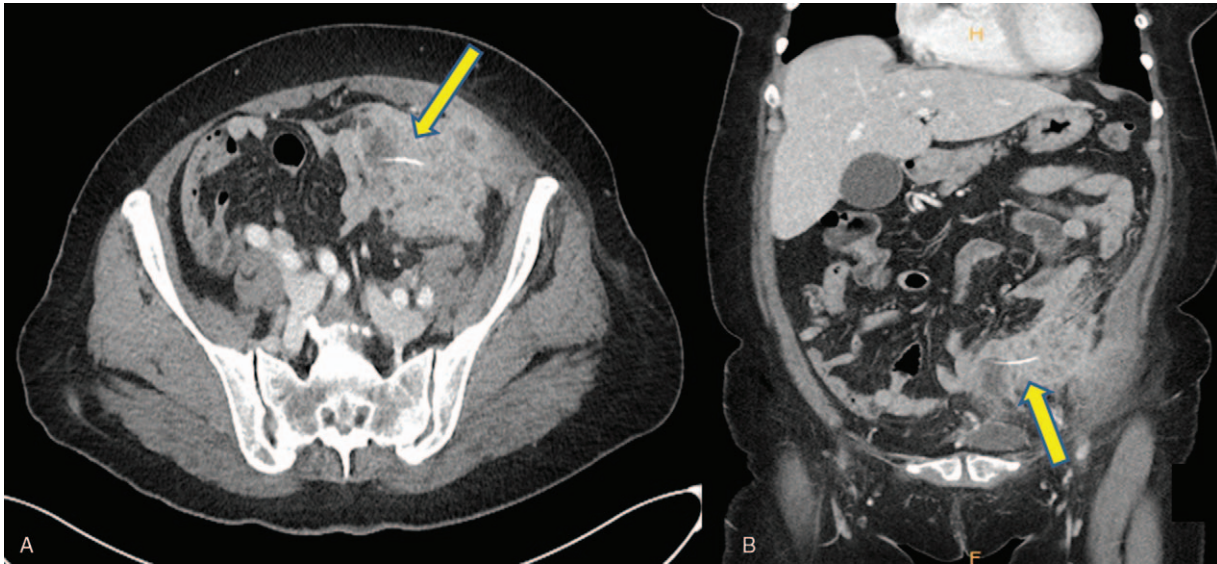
Abdominal pelvic computed tomography view: large inflammatory mass formation with adjacent left lower anterior abdominal wall enhancement and with linear high-density material within inflammatory mass, r/o foreign body including acupuncture needle or intrauterine device.
